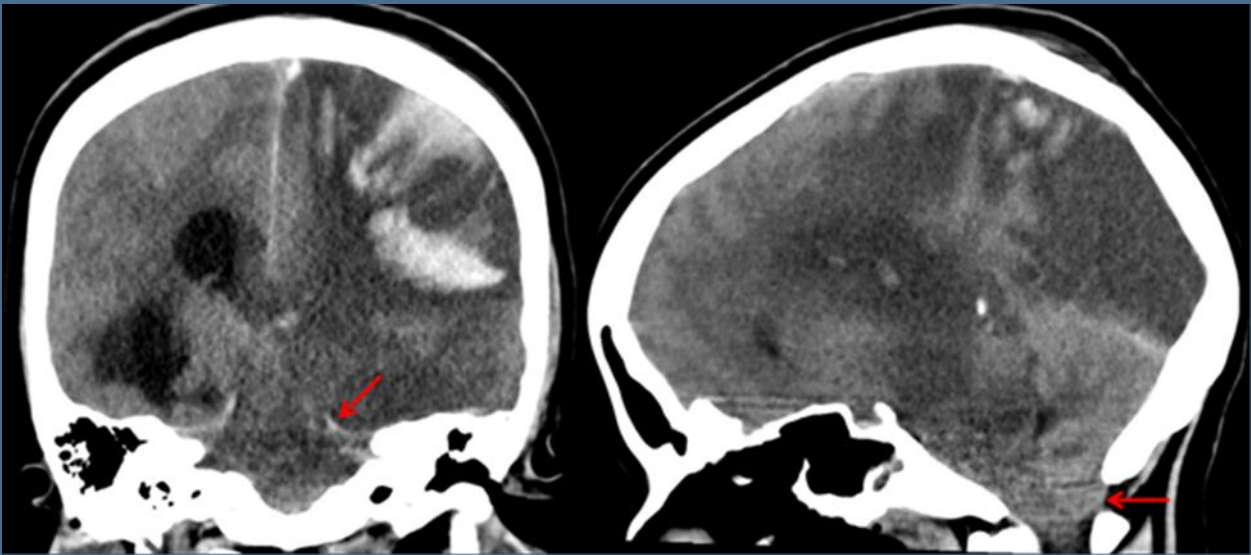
CT coronal (left) and sagittal image (right) showing uncal and tonsillar herniation.
